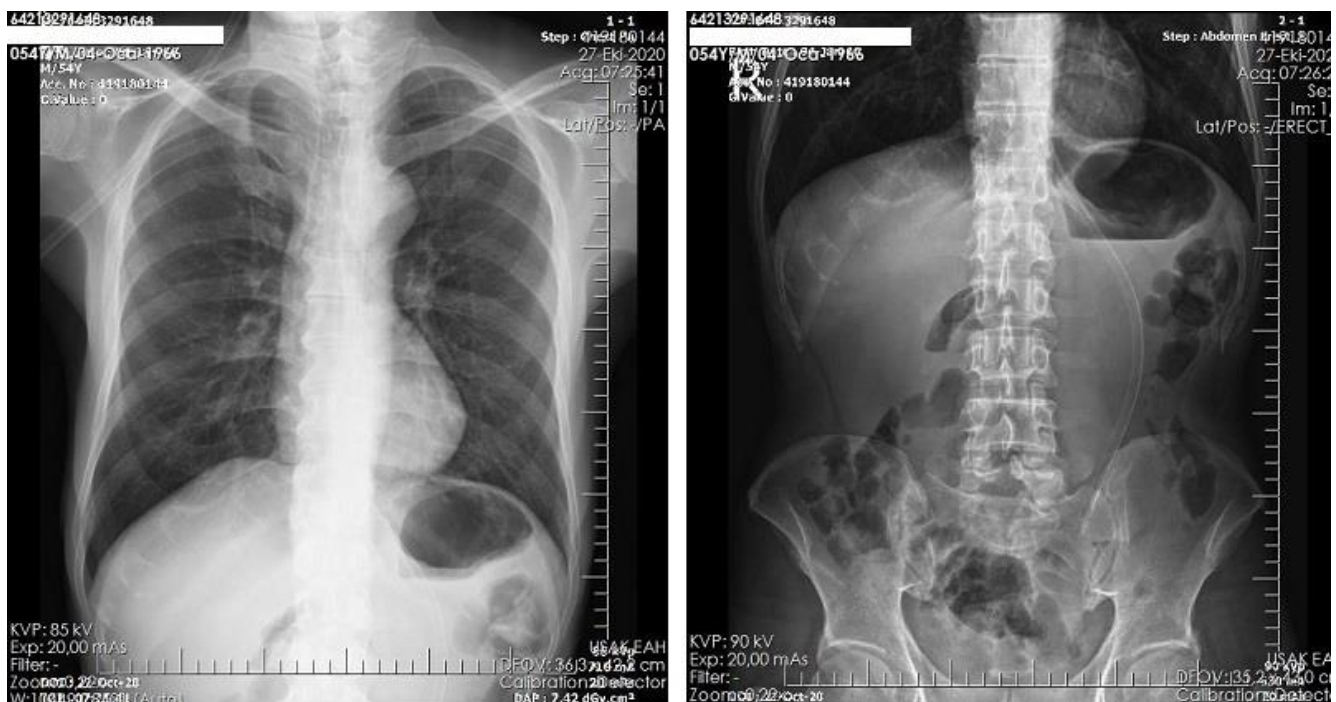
Abdominal and lung x-rays
